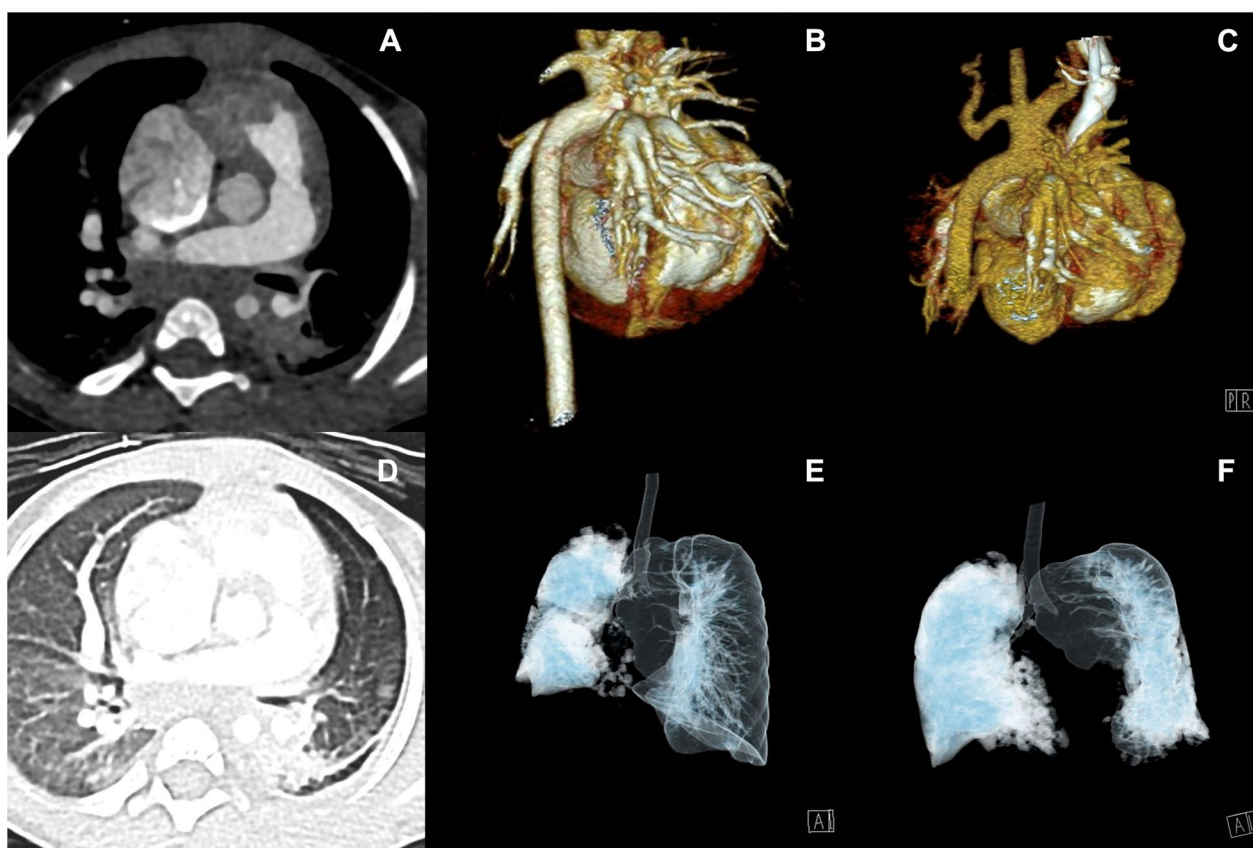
Postoperative imaging data. a. The postoperative enhanced CT demonstrated a posterior displacement of the thoracic aorta; b-c. The 3D reconstruction results demonstrate that, in comparison to the preoperative state (b), the distance between the aorta and the pulmonary artery has significantly increased postoperatively (c); d. The postoperative lung CT scan demonstrated a notable improvement in the emphysema of the left lung; e-f. The 3D reconstruction of the postoperative airway (f) revealed a marked improvement in pulmonary ventilation conditions compared to the preoperative state (e)
